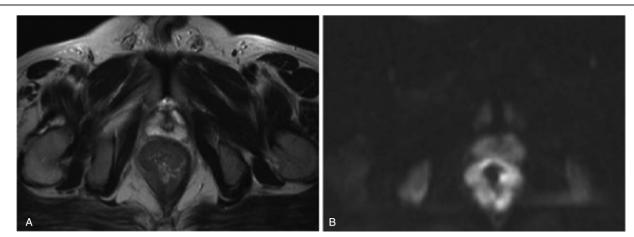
MR conventional sequence and DWI examinations for patients with rectal cancer in stage T4. High resolution T2WI in preoperative stage T4 (a); DW (lb = 1000 S/mm²) in preoperative stage T4 (b).
